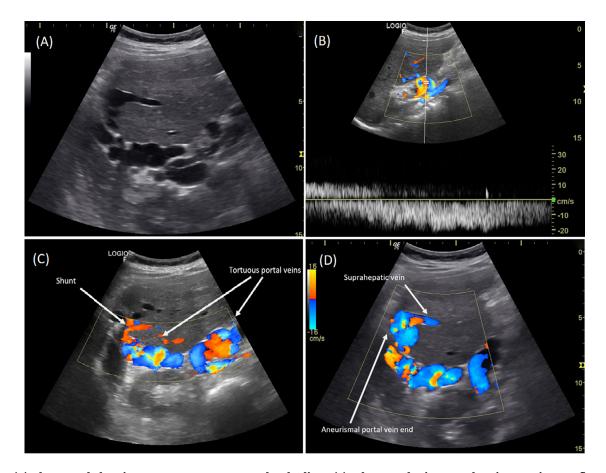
(A) Ultrasound showing tortuous structures under the liver; (B) color Doppler images showing continuous flow of the tortuous portal veins; (C) ultrasound at the level of the suprahepatic veins showing tortuous veins originating from the portal system joining the suprahepatic veins; (D) color Doppler images showing the aneurysmal portal system vein communicating with the right suprahepatic vein
